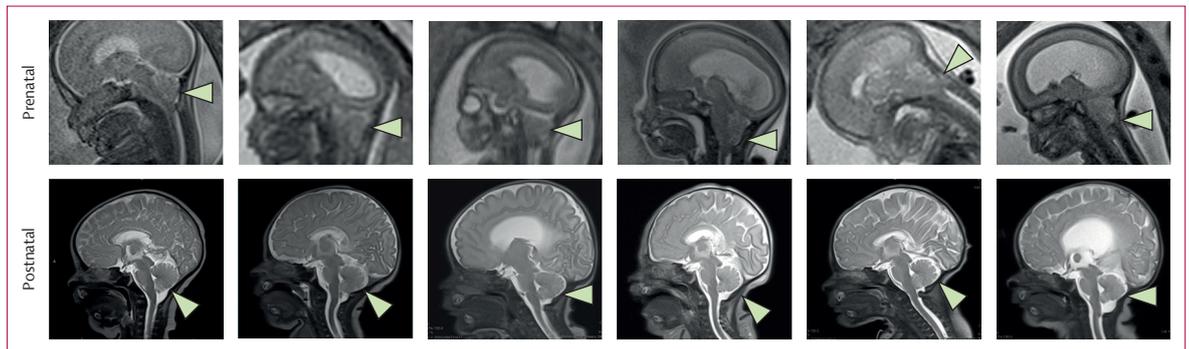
Prenatal and postnatal MRI showing reversal of hindbrain herniation following in-utero myelomeningocele repair with PMSC-ECM
